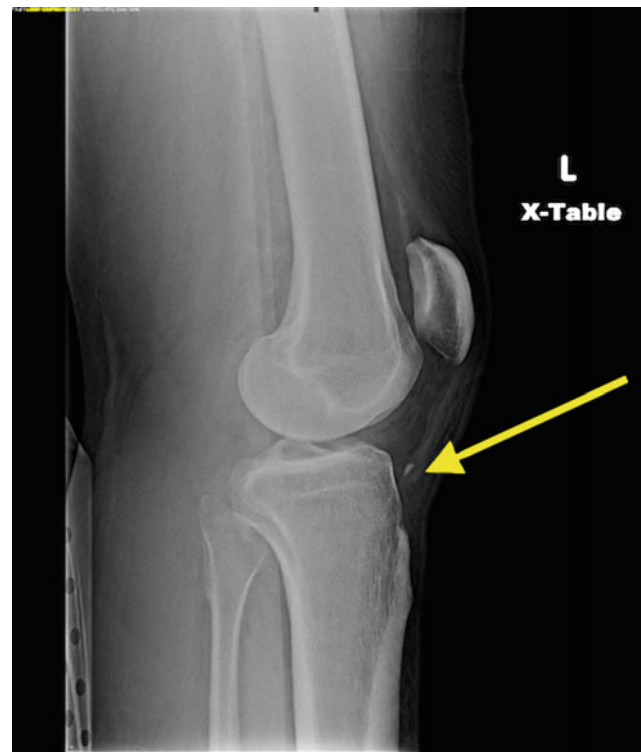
Lateral radiograph demonstrating patella alta secondary to a patellar tendon avulsion off the tibial tubercle in a multiple ligament injured knee. Note the yellow arrow marking the small avulsion fragment off the tibial tubercle
